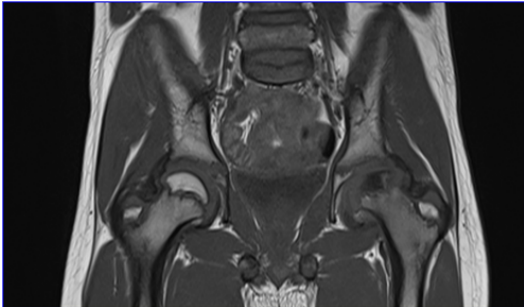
coronal T1WI MRI of a female child shows unilateral perthes involving the left femoral head. .
